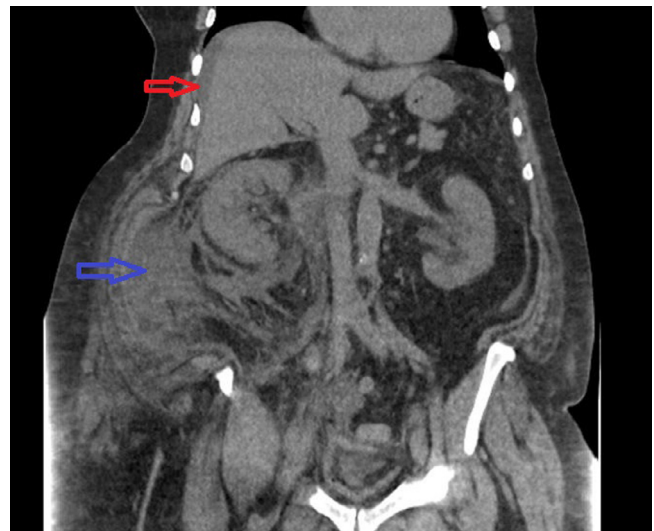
CT abdomen without contrast reveals increased infiltration of fat as well as a moderate amount of ill-defined fluid seen around the right kidney representing a ruptured calyx (blue arrow) with fluid tracking around the liver up to the diaphragm (red arrow).
